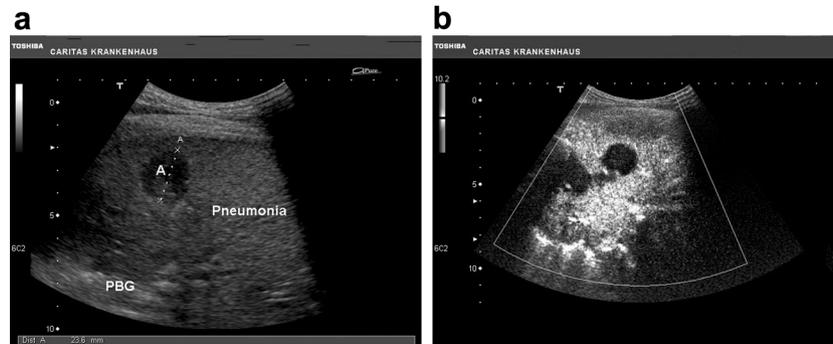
B-mode ultrasound (a) and contrast-enhanced ultrasound (b) images of pneumonia with abscess. The abscess formation is identified as a non-enhancing area (b). The pneumobronchogram is also indicated (PBG).
